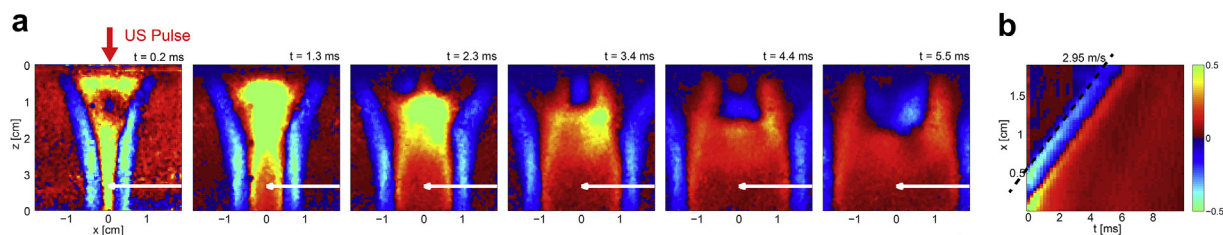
Shear wave propagation as detected by the research system. (a) High-frame-rate tissue Doppler images of travelling shear waves. The shear waves are displacing away from the external acoustic radiation force push focal zone, in a few selected successive frames; time is noted, with $t = 0$ ms at the push. The *white arrow* represents the virtual M-mode line. (b) Virtual M-mode along the line in (a). The slope of the wave front is tracked with a Radon transform in a region of interest with the research system, giving a velocity estimate of 2.95 m/s in this recording.
